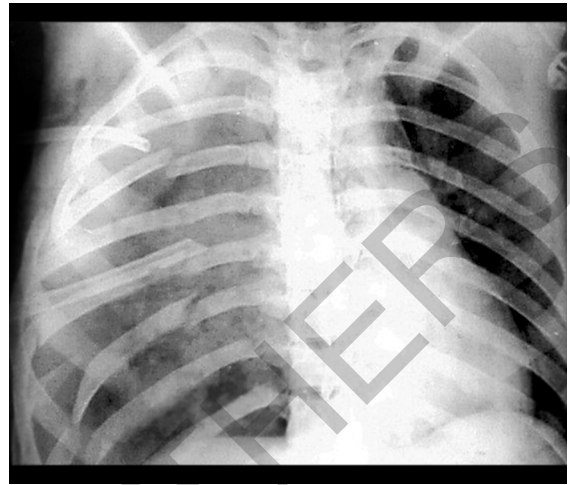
Chest X-ray—rib fractures involving three or more adjacent ribs, or multiple fractures of two or more ribs will increase opacity.
